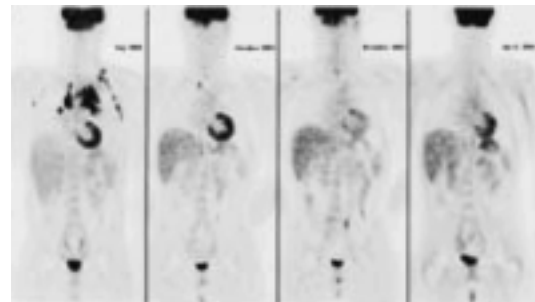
Treatment follow-up in lymphoma over a 1-year period. Many of these patients will receive more than a single PET/CT study.
